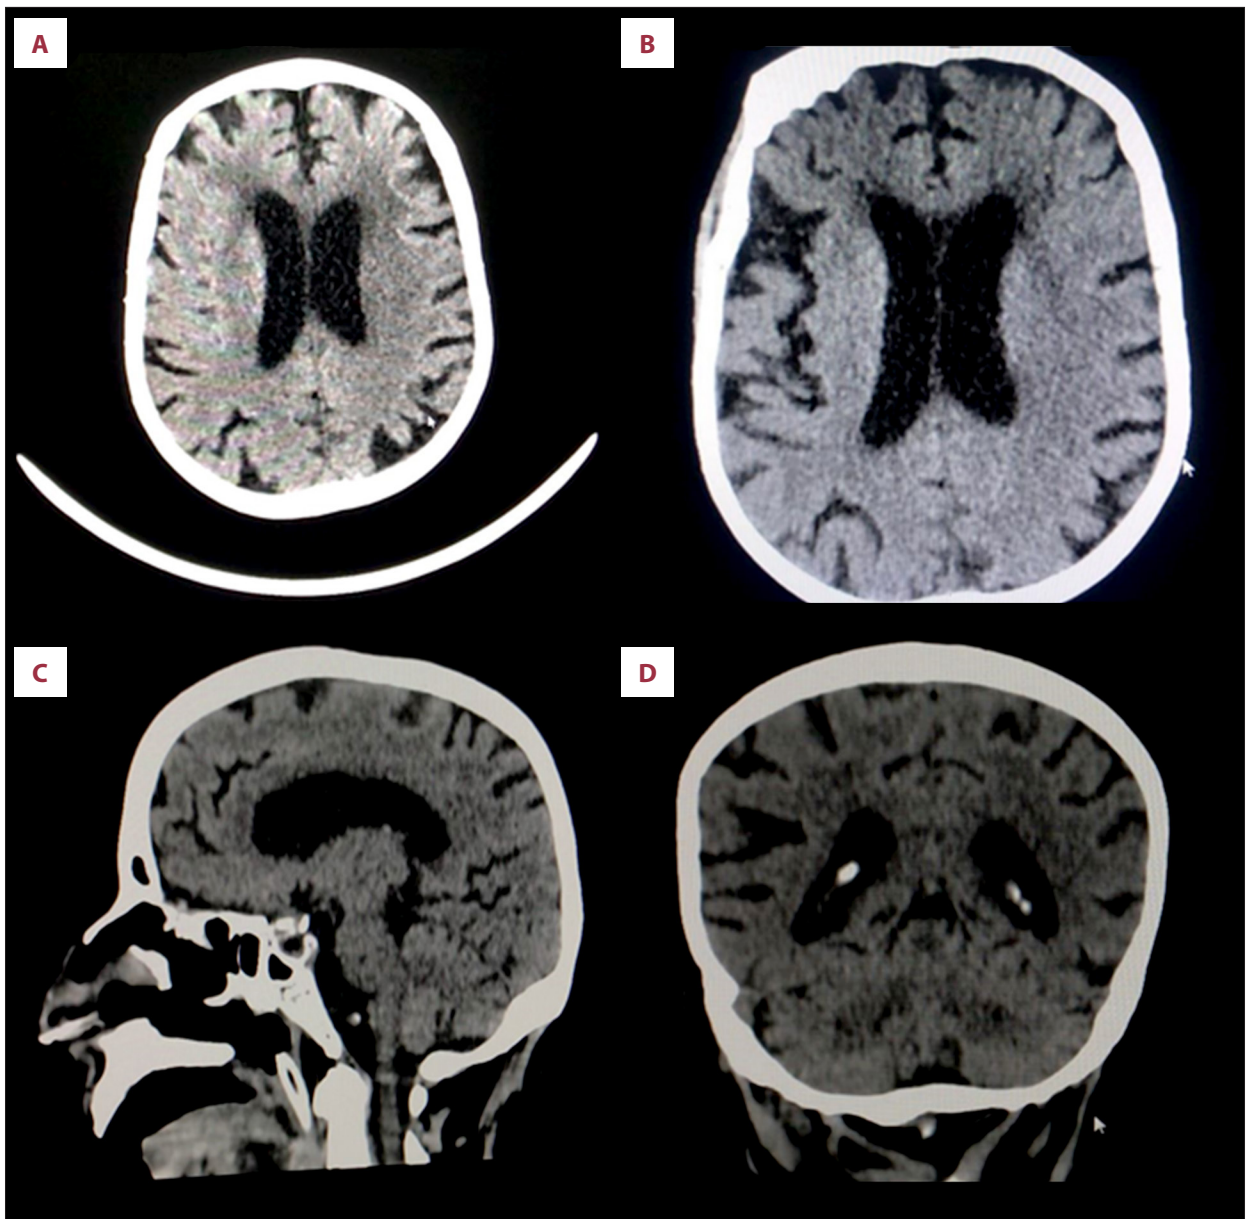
Multiple images of brain computed tomography scan (CT scan) without intravenous contrast show age-related brain atrophic changes with neither acute brain lesions nor acute ischemic changes: (A, B) axial sections; (C) sagittal section; (D) coronal section.
